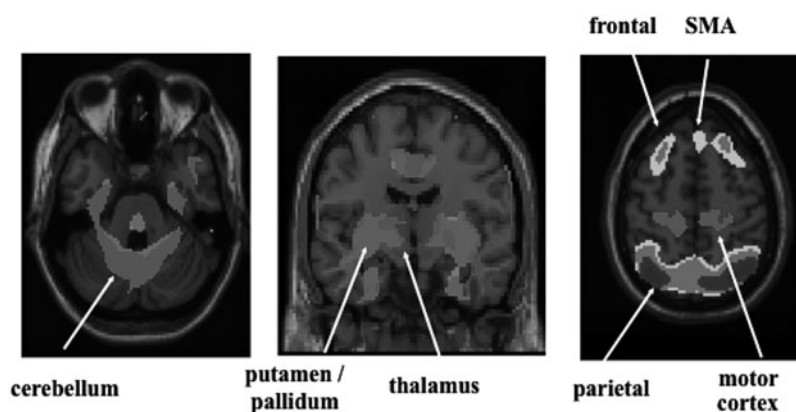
The PDRP of abnormal FDG uptake with relatively raised basal ganglia and reduced frontal and parietal glucose metabolism. *Source:* Picture courtesy of D. Eidelberg. (See Color Plate 9.3.3.)
